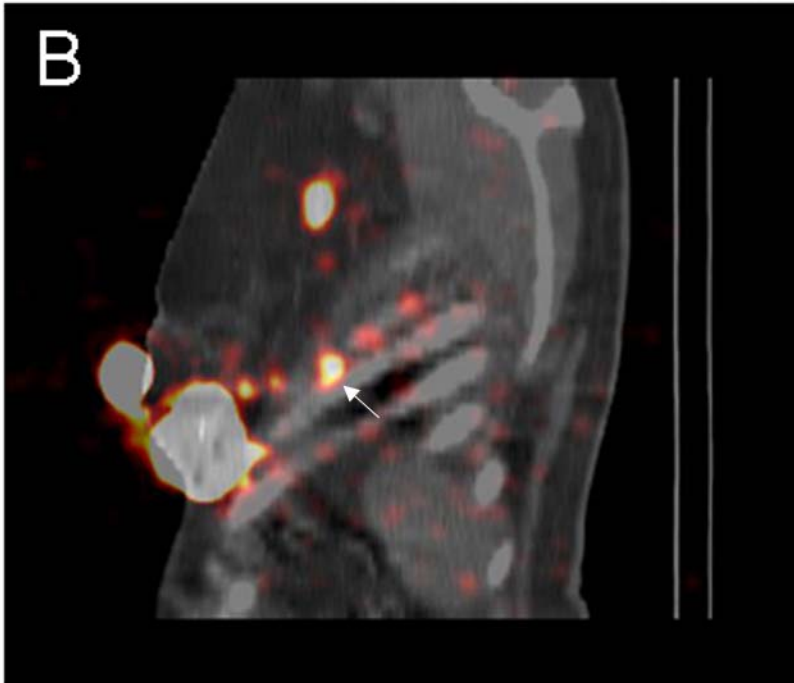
Patient with left breast cancer in the lower outer quadrant. The lateral planar view reveals axillary drainage and lateral nodes of uncertain location (arrow) (A). SPECT/CT clearly depicts three consecutive costal nodes (arrow) in addition to the axillary nodes (B-sagittal view).
